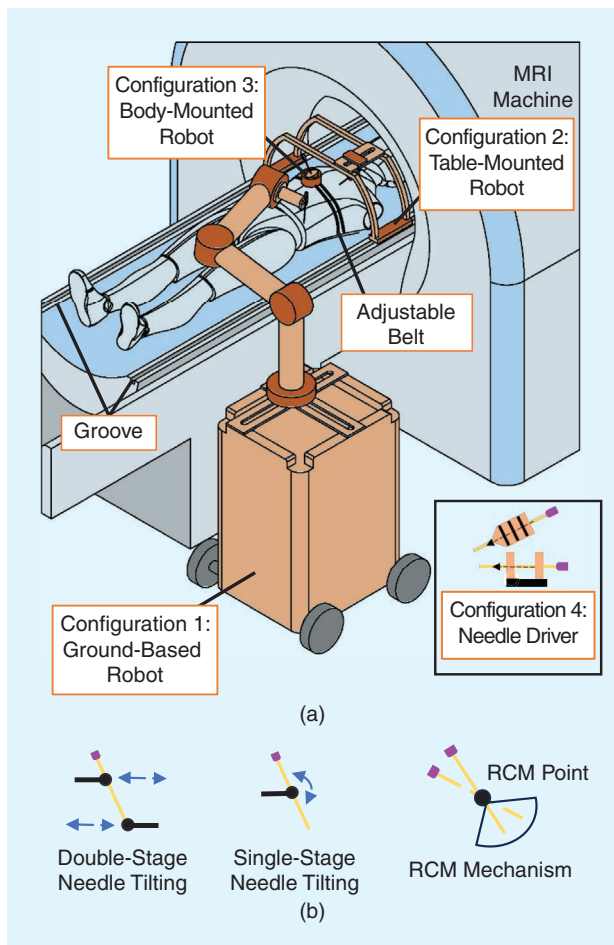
Robotic systems and needle drivers configurations (a) The four configurations for MRI-guided interventional robotic systems for needle insertion: configuration 1, ground-based robot; configuration 2, table-mounted robot; configuration 3, body-mounted robot; and configuration 4, needle driver. (b) Needle driver configurations to control needle tilting. RCM: remote center of motion.
